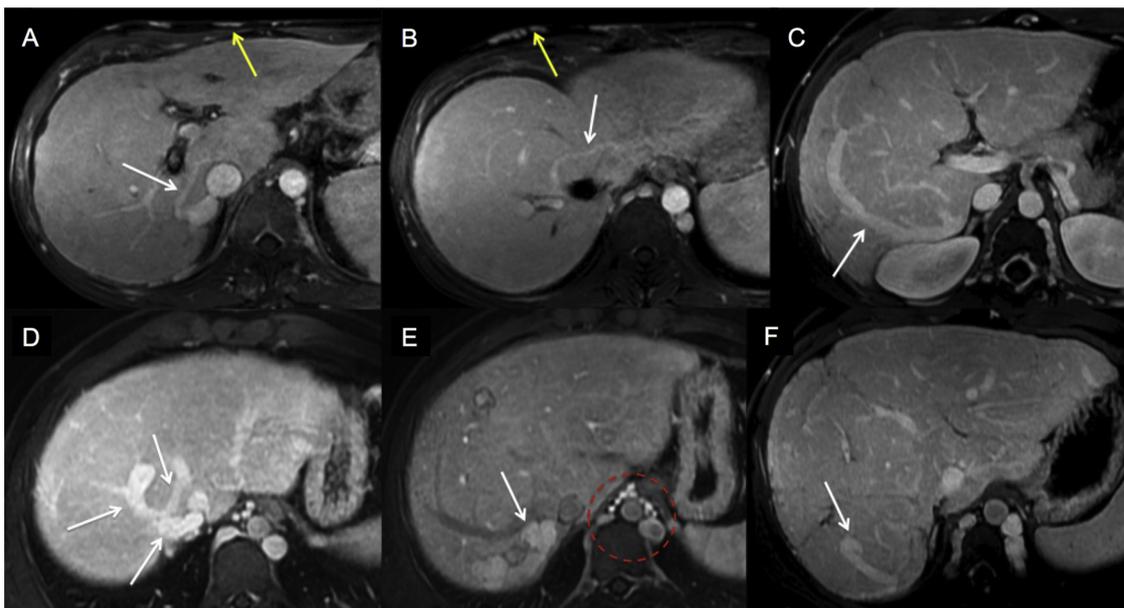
Venous shunts in BCS. Axial portal phase MR images showing multiple veno-venous shunts (white arrows) in different patients. Notice the caput medusae (yellow arrows) and esophageal varices (red circle) as signs of portal hypertension.
